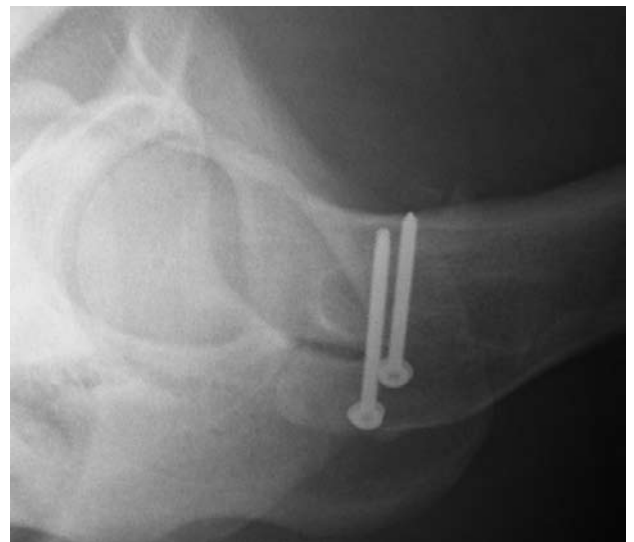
Lateral view of Hip x-ray
